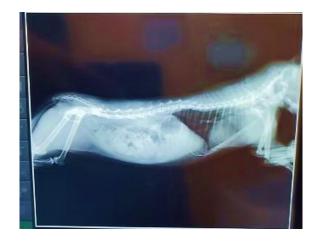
Thoracic radiography
